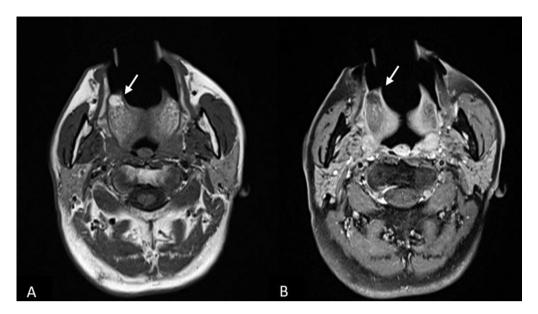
Preoperative magnetic resonance imaging (MRI) of the tongue mass. (A) Transverse T1-weighted MRI showing a well-defined, ovoid-shaped mass with homogeneous high-signal intensity. (B) Transverse, fat-suppressed T1-weighted, gadolinium-enhanced MRI showing attenuated signal intensity inside the lesion.
